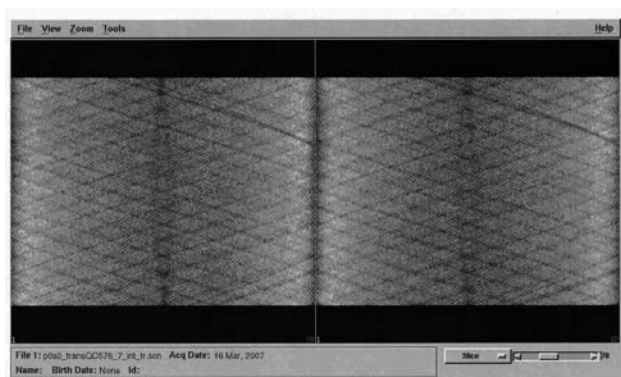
An example of detector stability acquisition on a Philips Gemini PET/CT using a ^{137}Cs rotating source (courtesy: L. Indovina and A. Giordano, Catholic University, Rome).
